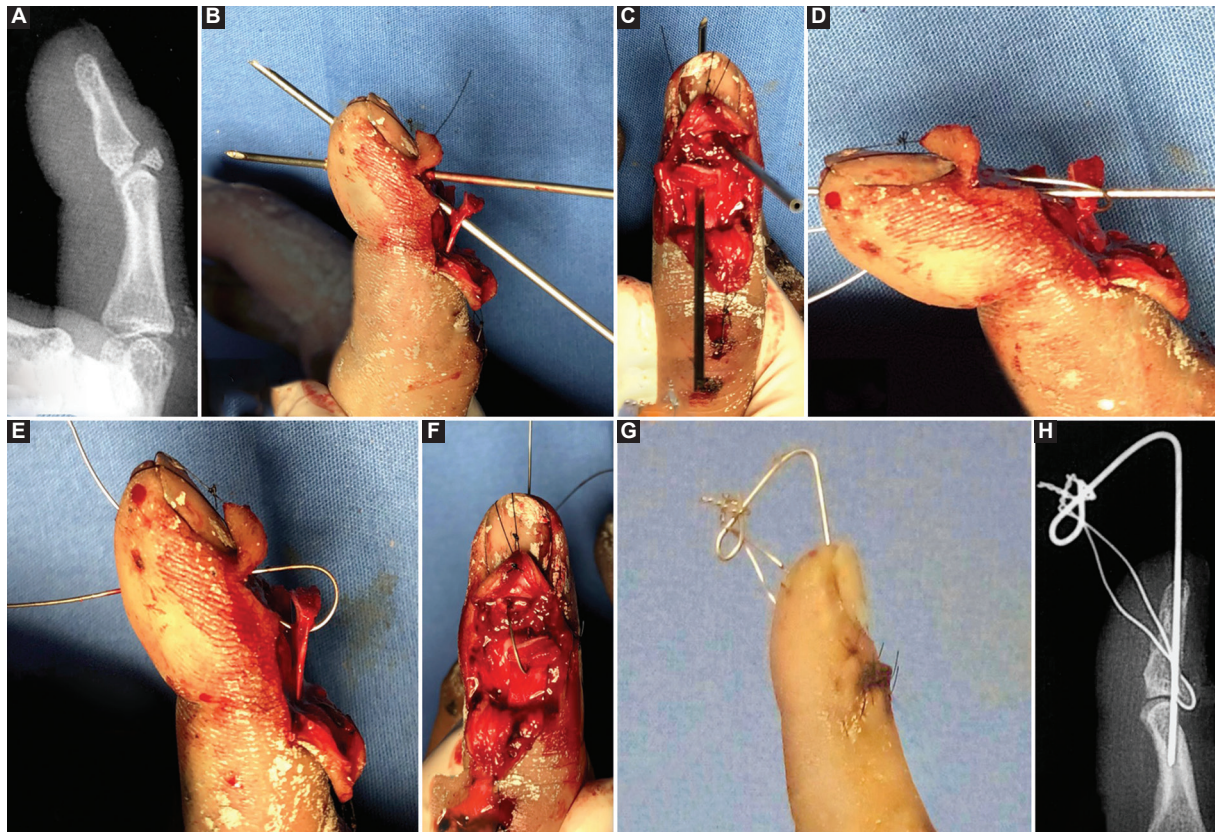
Case example showing the technique. A: radiograph. B: the two trochars on the respective place. C: dorsal view of trochar placement. D: lateral view. E: The bony fragment. F: dorsal view. G: 7 days after surgery. H: control radiograph.
